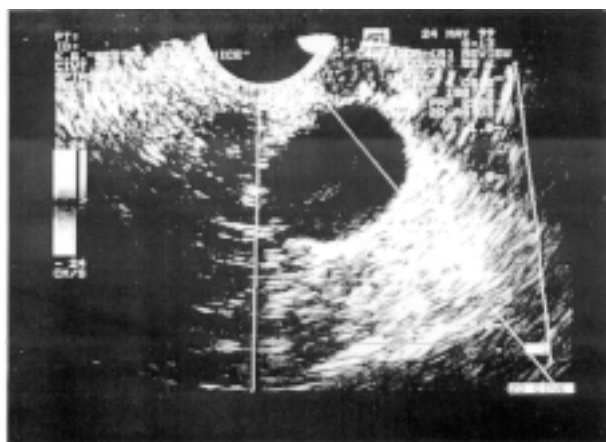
Brenner tumor: sonographic scan in a study patient.
